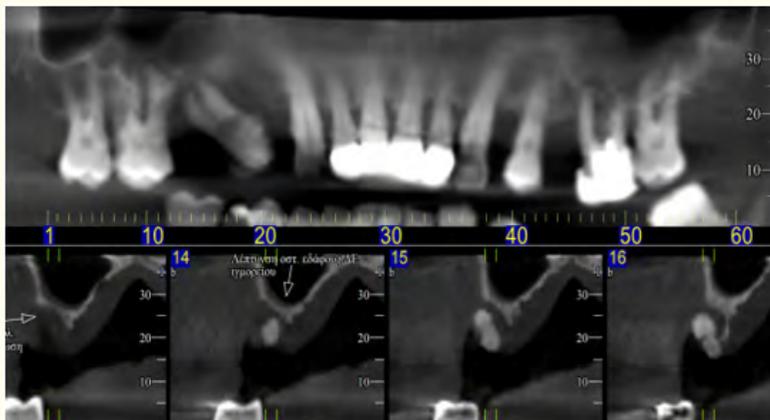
Pre-Op CBCT and details.
